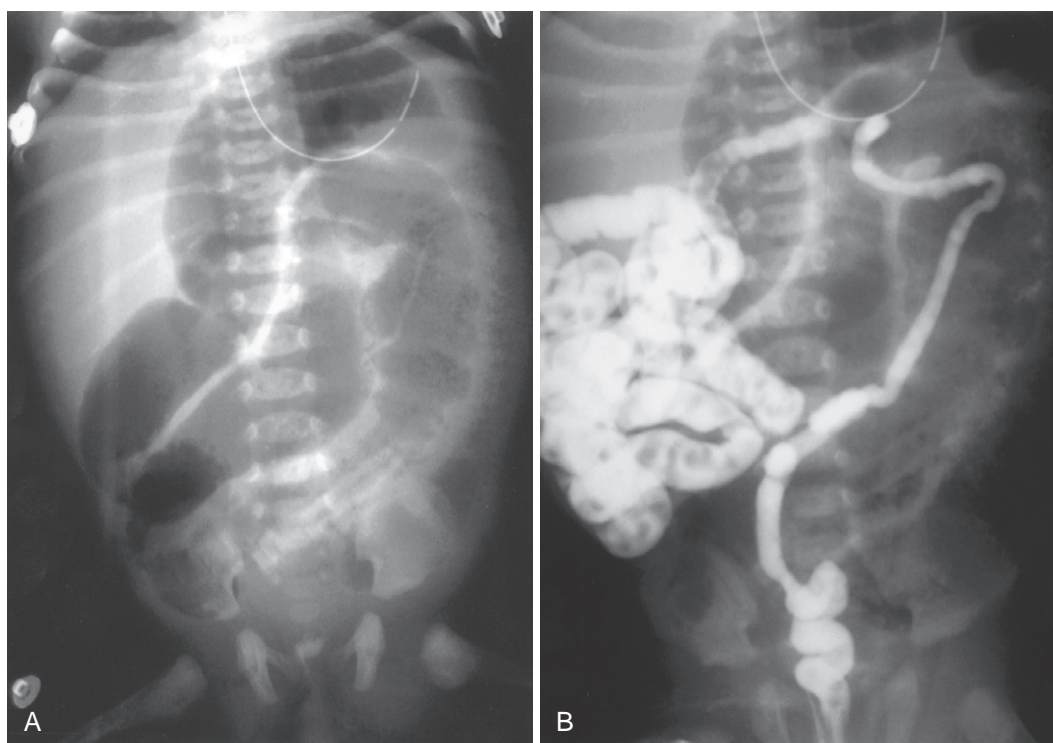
A, Abdominal plain radiograph is compatible with the diagnosis of meconium ileus. There are distended bowel loops of disparate size, few air-fluid levels, and a “soap bubble” right lower quadrant appearance. B, Same patient as in A is studied further with a contrast enema. A microcolon or unused colon is demonstrated, and contrast agent refluxes into dilated, more proximal small bowel where inspissated intraluminal pellets of meconium are seen. These findings strongly suggest the diagnosis of meconium ileus.
